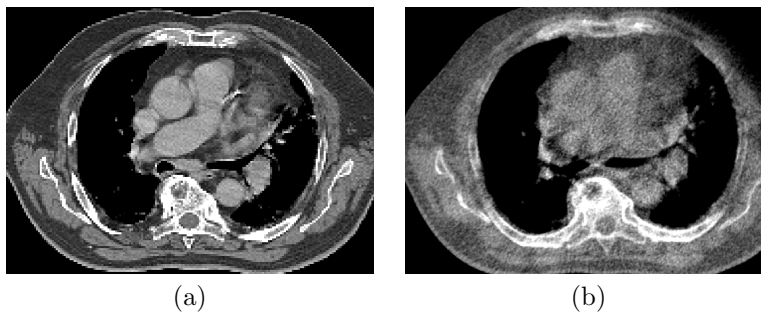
Two images of the same patient acquired with conventional CT (a) and MVCT(b).
